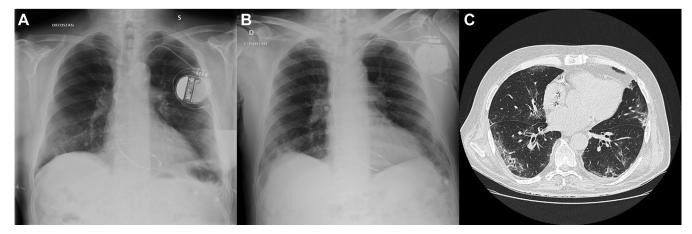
A: Chest radiograph within normal limits. B: Chest radiograph showing an area of lung dysventilation in the right lower lobe. C: Computed tomography scan of the chest showing bilateral pneumonia, with multiple ground-glass opacities and subpleural distribution.
